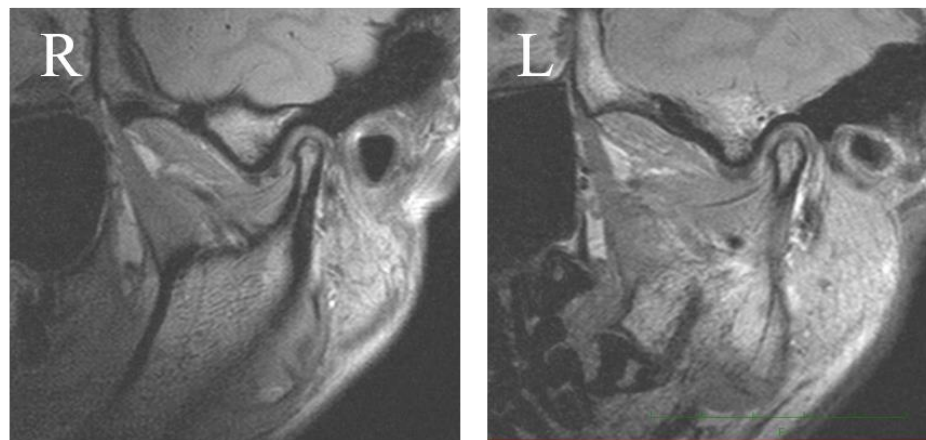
Sagittal MR image of temporomandibular joint.: R, right TMJ L, left TMJ.
